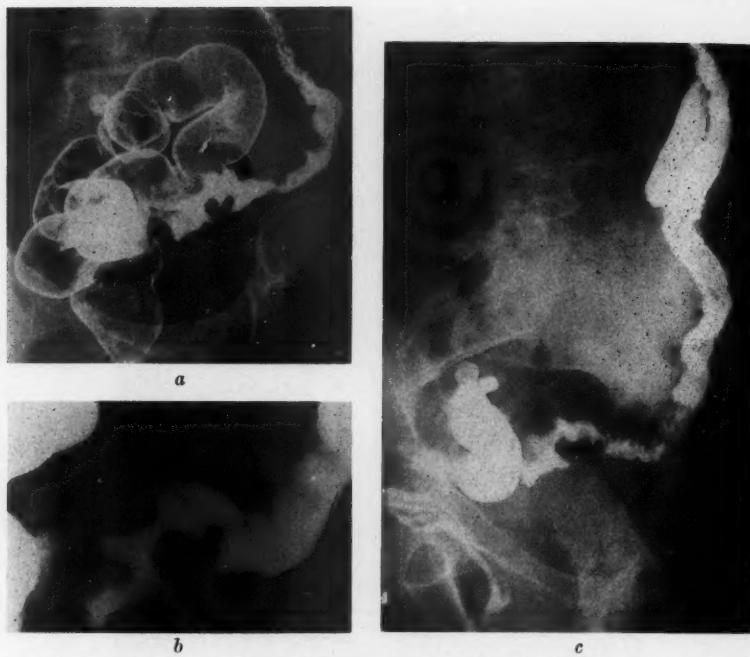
A perforating lesion of the upper part of the sigmoid. There is perisigmoidal abscess formation, and several fistulous tracts lead from the abscess cavity to the perisigmoidal soft tissue. There is no positive evidence of neoplasm. b. Spot roentgenogram of the lesion in a. c. Roentgenogram made after two weeks of medical treatment. It was the opinion of the roentgenologist that this lesion was malignant.
